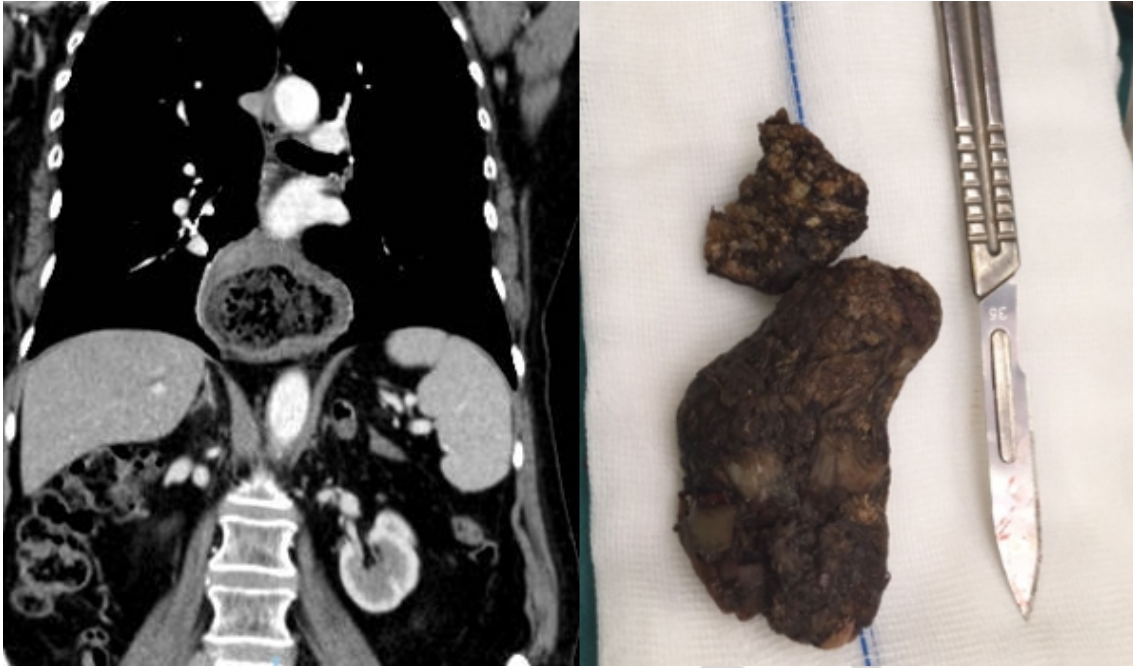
A. CT showing a bezoar in large hiatus hernia. B. The bezoar extracted after resection.
